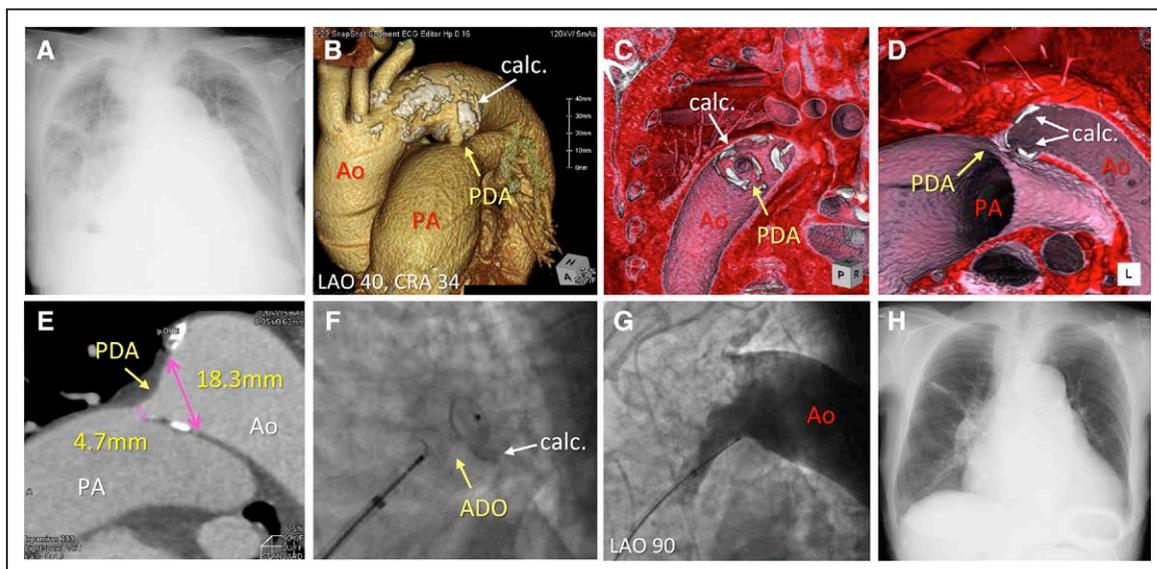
A, Chest radiograph shows severe pulmonary congestion and cardiomegaly. B–D, Reconstructed 3-dimensional computed tomography (CT) shows patent ductus arteriosus (PDA; yellow arrow) with severe calcifications (white arrow). E, PDA size measured by CT. F, Deployment of the Amplatzer Duct Occluder (ADO). G, Confirmation of complete occlusion of PDA on an aortography. H, Improvement shown on a chest radiograph (3 wk post-occlusion). Ao indicates aorta; calc, calcification; LAO, left anterior oblique; and PA, pulmonary artery.
